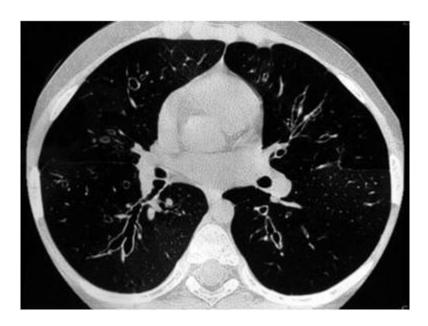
High resolution CT chest showed bilateral lower lobe bronchiectasis
